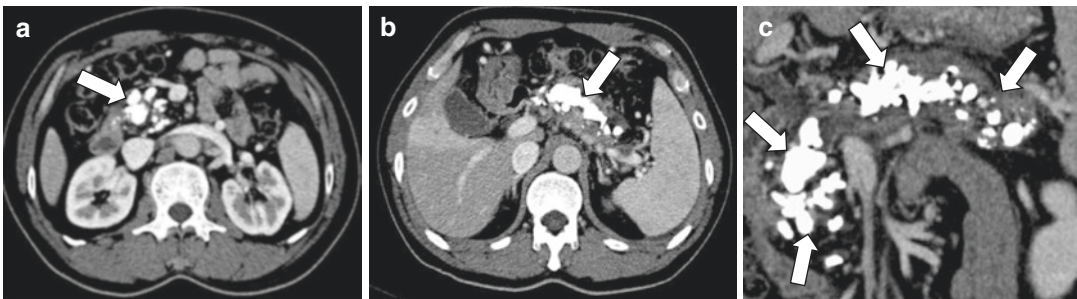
Chronic pancreatitis on CT. CECT axial images (a, b) show a dilated pancreatic duct, multiple calcifications (*arrows*) throughout the pancreas, and parenchymal
